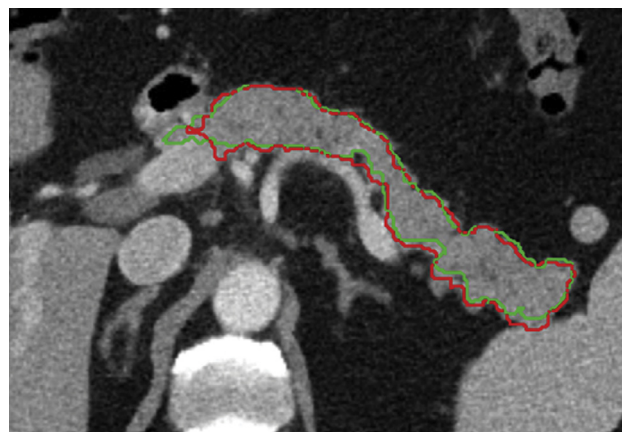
Automated (red) and manual tracing (green) of pancreas in a 52-year-old man. The pancreas is well-delineated by abundant peripancreatic fat. There is mild heterogeneity of intrapancreatic CT attenuation. DSC = 0.84. Standard Deviation of pancreatic attenuation = 33.1 HU. Average Attenuation of Pancreatic Neighborhood = -35.1 HU. (Color version of figure is available online.)
